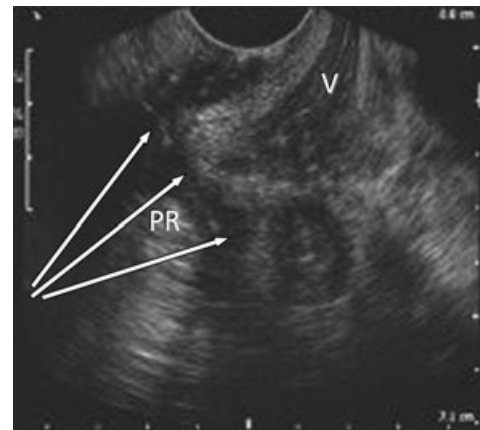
Example of an erroneously diagnosed suprasphincteric fistula on transperineal ultrasound in a patient with anal canal stenosis. The sagittal image shows the vagina (V) and the puborectalis (PR) with a circuitous fistula (arrows) tracking around the puborectalis muscle. At operation the fistula was found to be of infralevator trans-sphincteric type with a translevator extension and an internal opening at the dentate line rather than a true suprasphincteric fistula.
